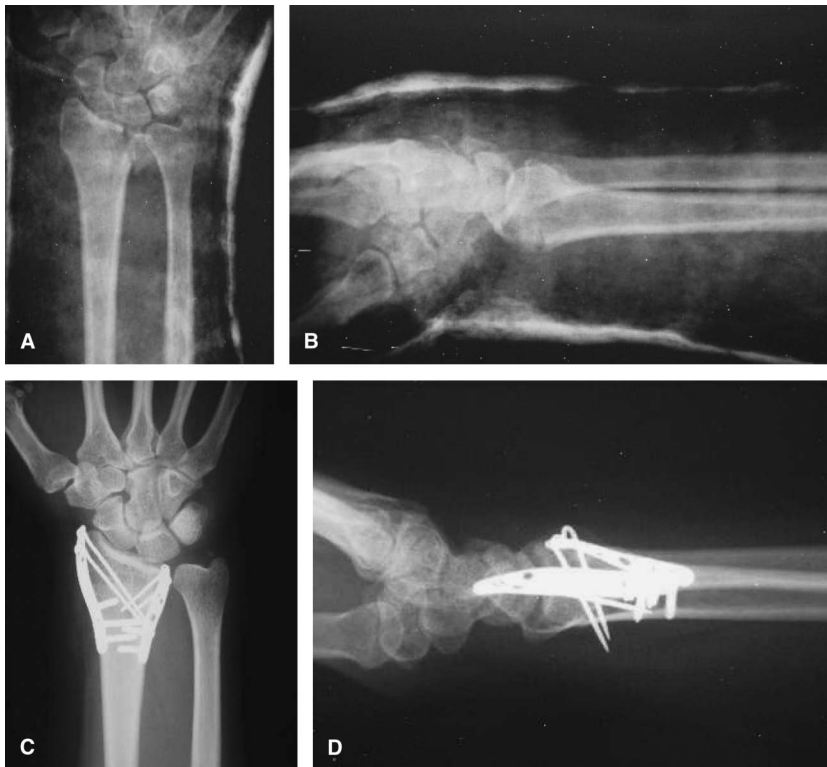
Preoperative and postoperative radiographs demonstrating the use of the radial and ulnar pin plate. The lunate facet was elevated and temporarily held in place with a 0.045 K-wire. The K-wire was then supported and secured with an ulnar pin plate. Two K-wires were used with the ulnar pin plate.
